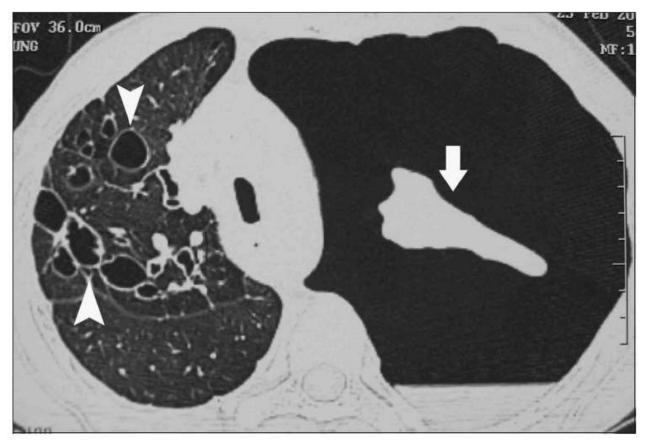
Axial HRCT (lung window) in a patient of ABPA who presented with a left-sided spontaneous pneumothorax (arrow). Extensive central and peripheral bronchiectasis is seen involving the right lung (arrowheads)
